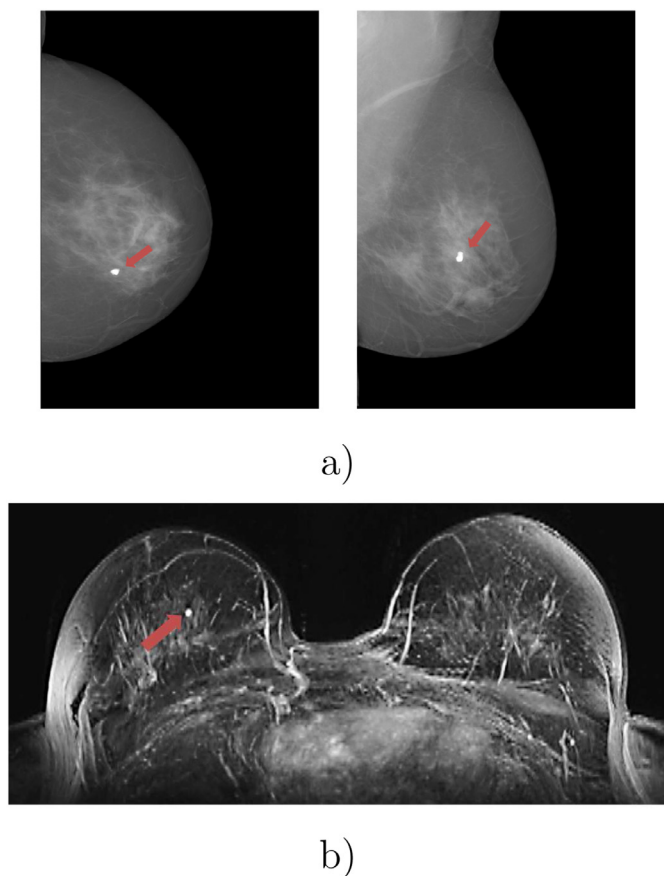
Lesion in (a) CC and MLO mammograms and (b) the maximum intensity projection of the lesion in the DCE-MRI. The lesion position is localized using a red arrow in the images. (For interpretation of the references to colour in this figure legend, the reader is referred to the web version of this article.)
